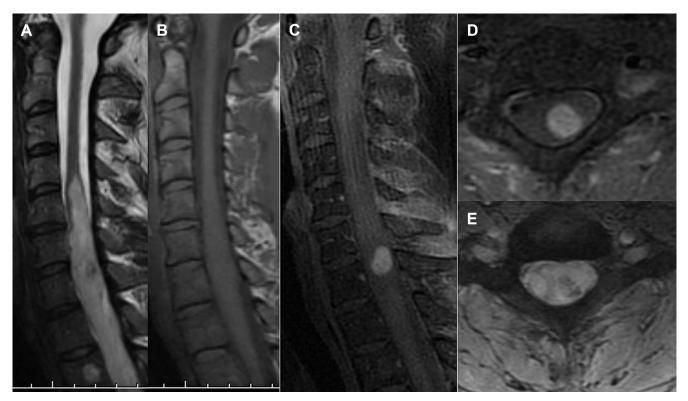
(A) Sagittal T2-weighted magnetic resonance imaging (MRI) demonstrates cord expansion with increased signal intensity from C4 through the visualized T2 level. A T2 nodular hypointense focus is identified at C6–C7. (B) Sagittal T1-weighted MRI demonstrates isointense fusiform expansion of the cervical spinal cord from C5 through T1 levels. (C) T1 fat suppression postgadolinium sagittal and (D) axial MRIs demonstrate a well circumscribed eccentric nodular focus of enhancement at the C6–C7 level. (E) Gradient echo axial sequence exhibits susceptibility artifact consistent for a small hemorrhagic component.
